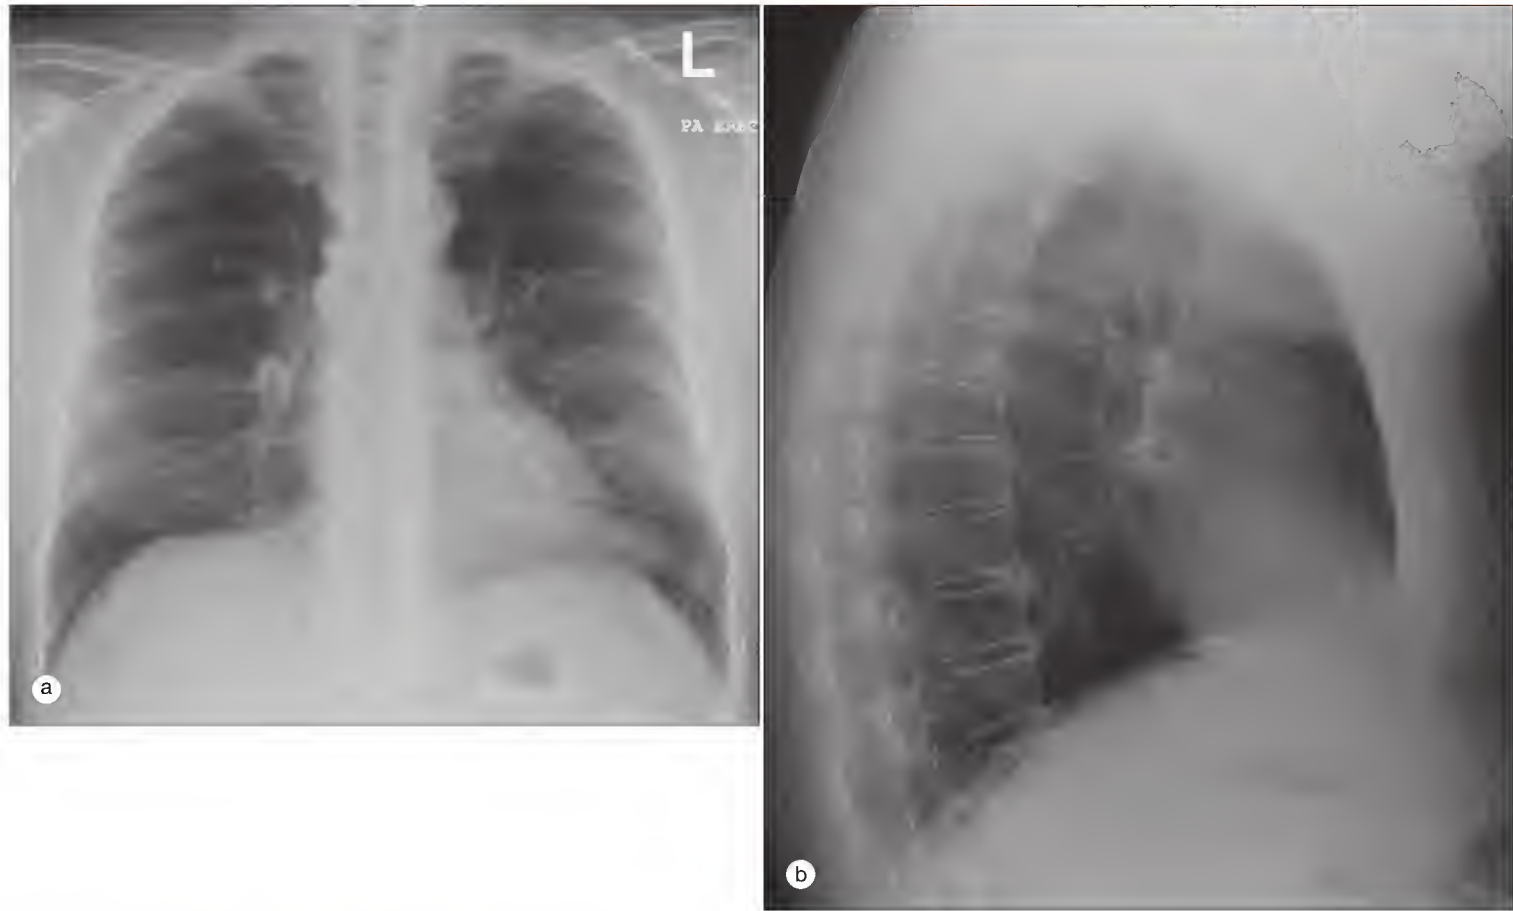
Typical radiographic findings in the thoracic spine on routine chest radiographs in posteroanterior (a) and lateral (b) views, with “flowing” new bone formation linking four contiguous vertebrae, predominantly right-sided, in the absence of intervertebral disk change.
